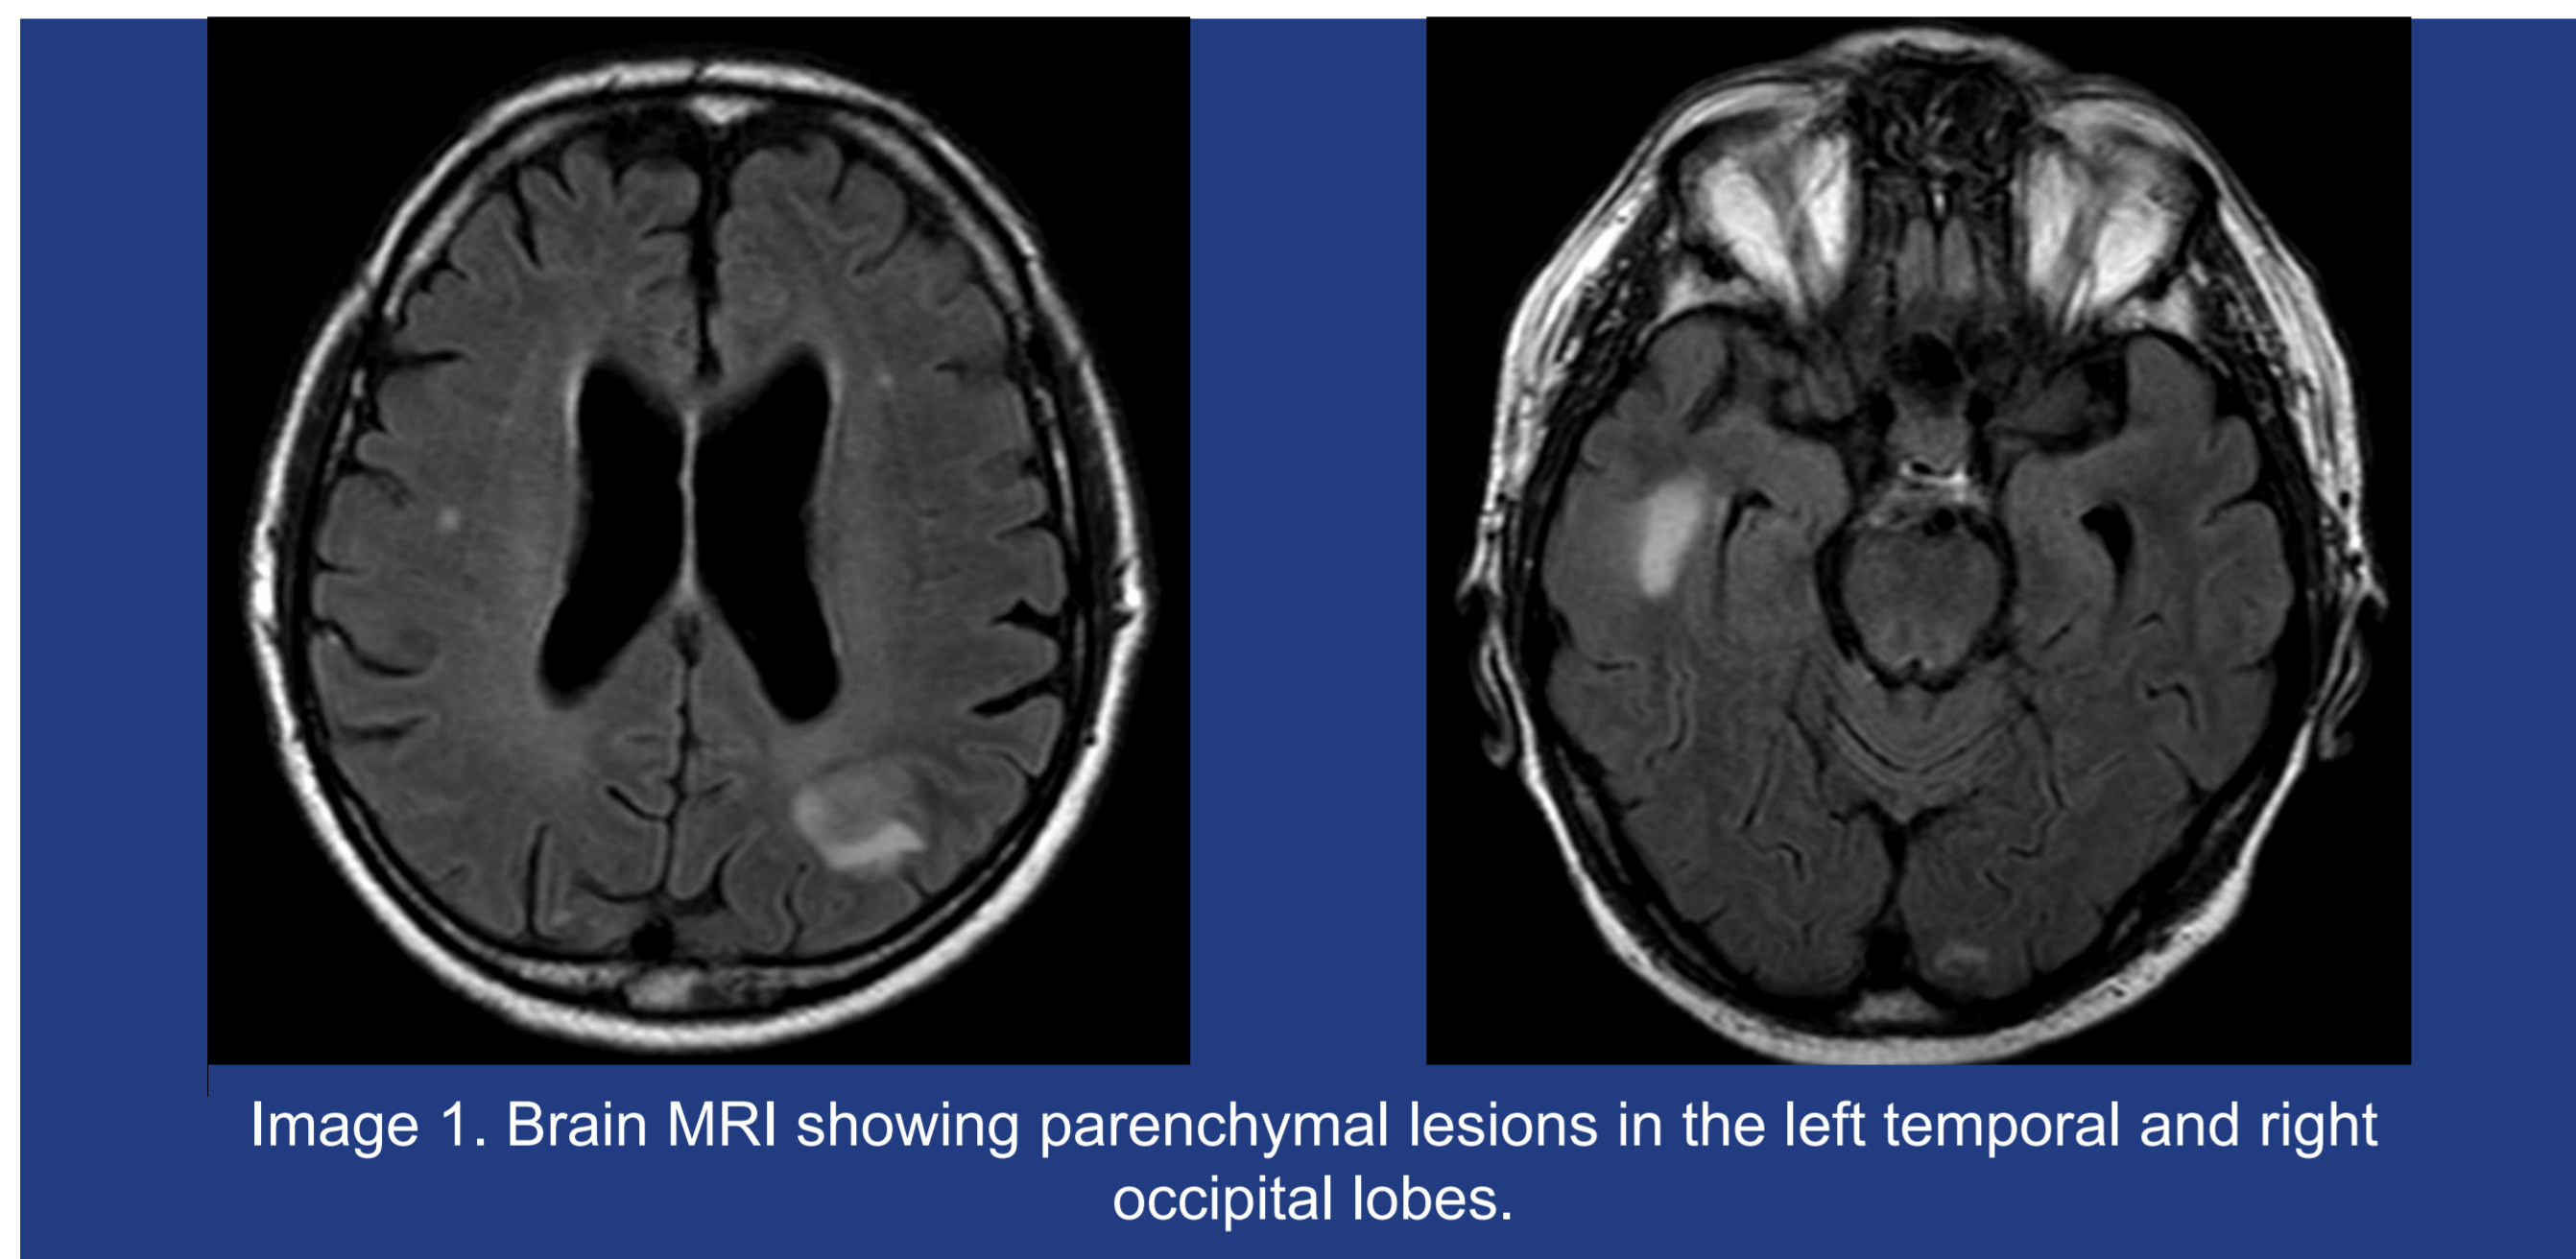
Brain MRI showing parenchymal lesions in the left temporal and right occipital lobes.
